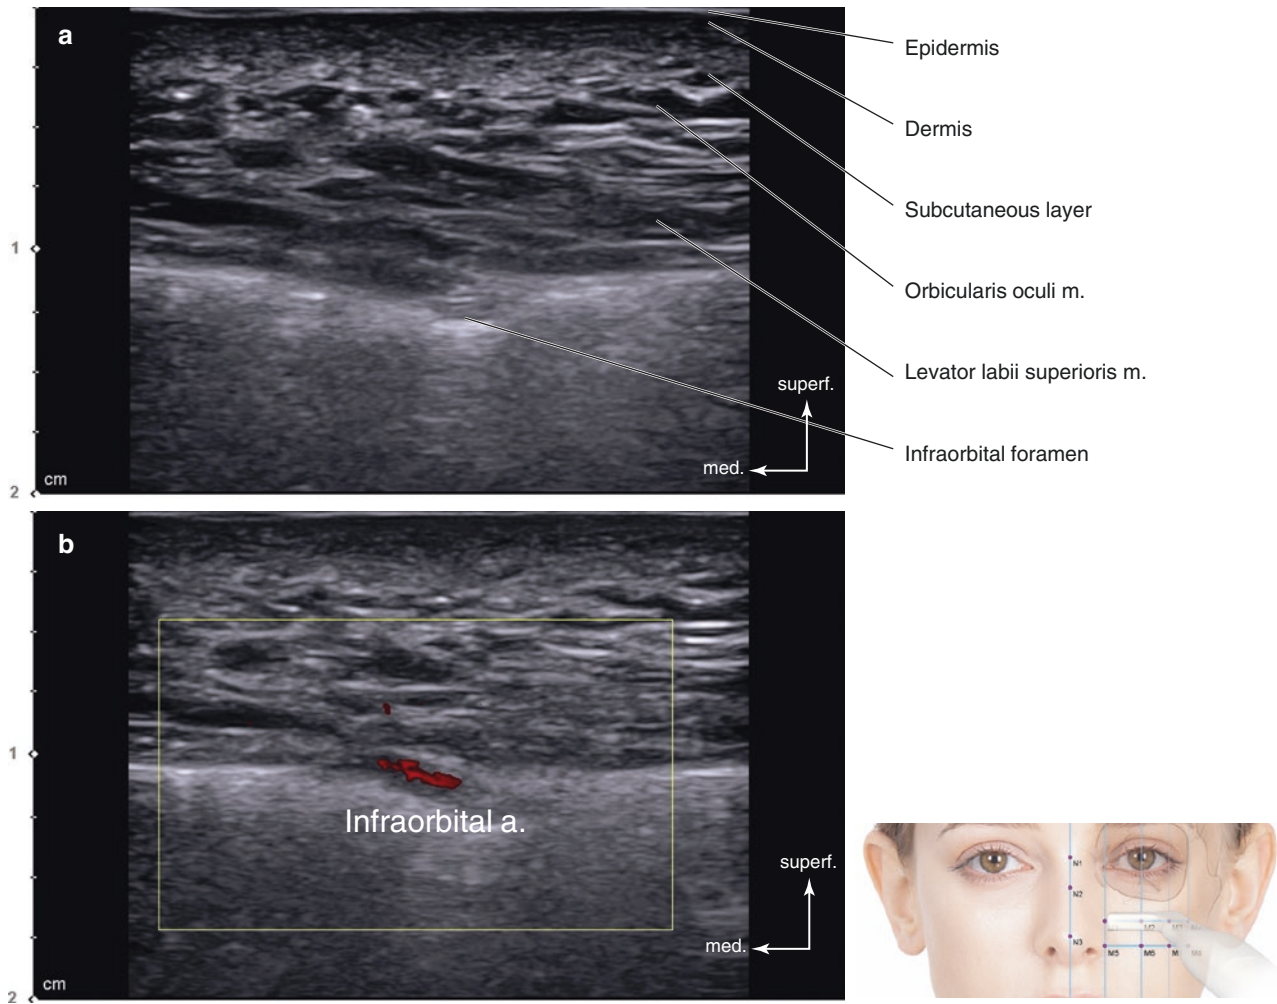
Ultrasonography on the intersection point of TL4 and PL2 (M2). (a) B mode (transverse view, 15 MHz by linear transducer), (b) Doppler mode (transverse view, 15 MHz by linear transducer), (c) B
